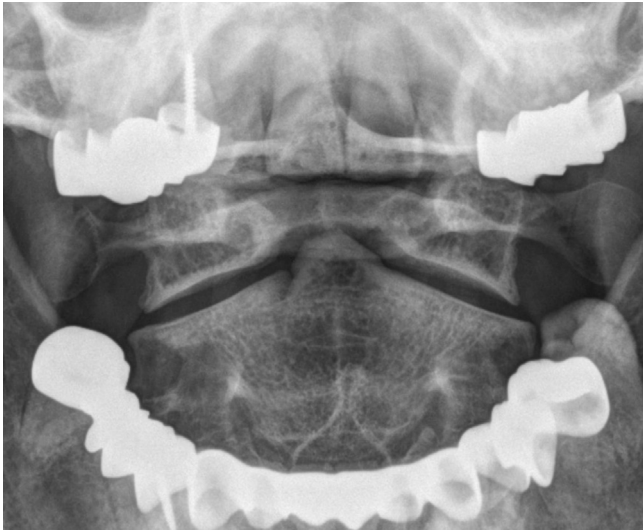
Radiographs of the cervical spine revealing a type II odontoid process fracture.
